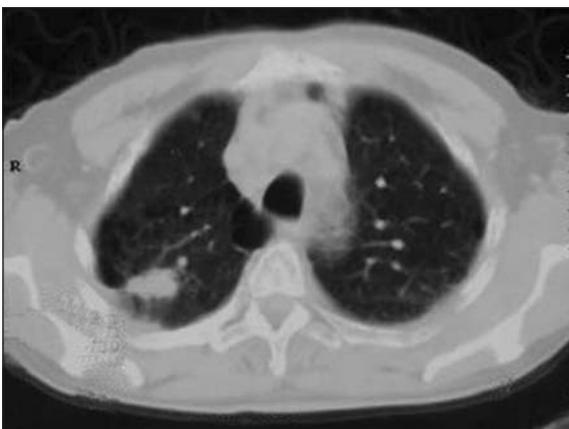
CT scan revealed a hypodense nodule (2 x 2.5 x 2 cm) with irregular contours in the posterior segment of upper lobe of the right lung localized in subpleural zone.
